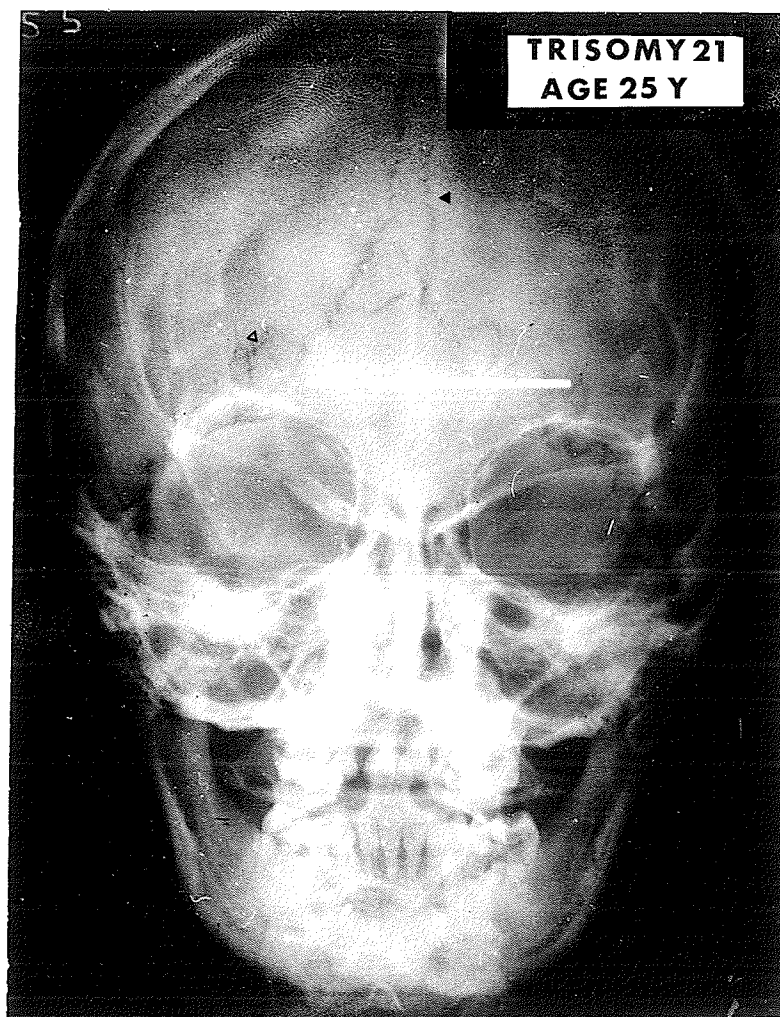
A P.A. radiograph of an adult Trisomy 21 individual showing a patent metopic suture and sutural bones.
